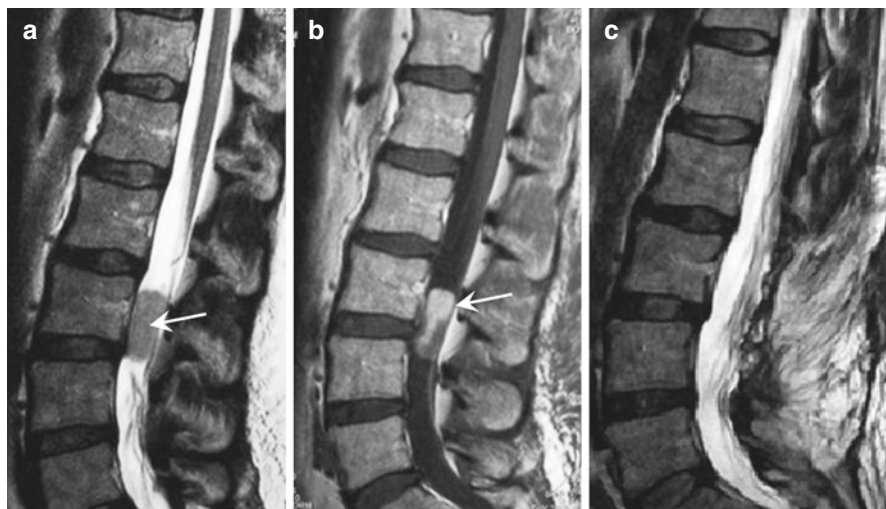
Imaging of a 47-year-old female patient with paraparesis, L2 sensory level, and bowel incontinence (patient operated on by the senior author [KIA]). (a) Preoperative sagittal T2-weighted MRI of the lumbar spine demonstrating myxopapillary ependymoma at L3 segment (arrow) Type IB. (b) Preoperative sagittal post-contrast T1-weighted MRI of the lumbar spine. Complete resection of the tumor was performed. The patient recovered completely and was neurologically intact. (c) Postoperative T2-weighted MRI of the lumbar spine demonstrating complete resection
